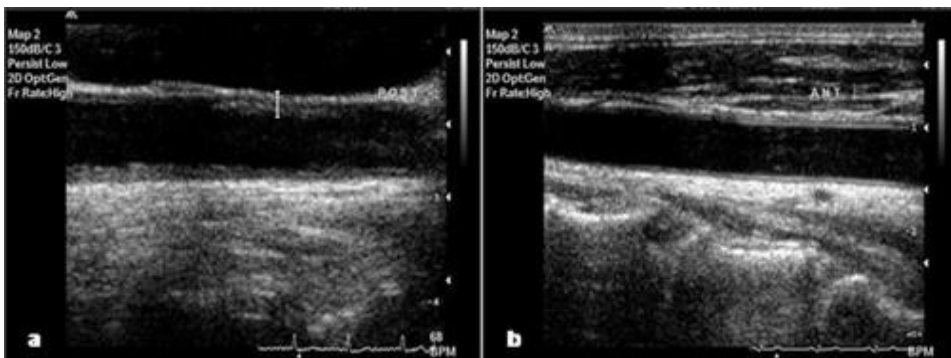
Figure legend: Figure 1: Increased (a) and normal (b) intima-media thickness (IMT) of the common carotid artery (CCA) in SLE patient and control respectively by Doppler ultrasonography. The thickness is denoted by the white line from the cursor.
